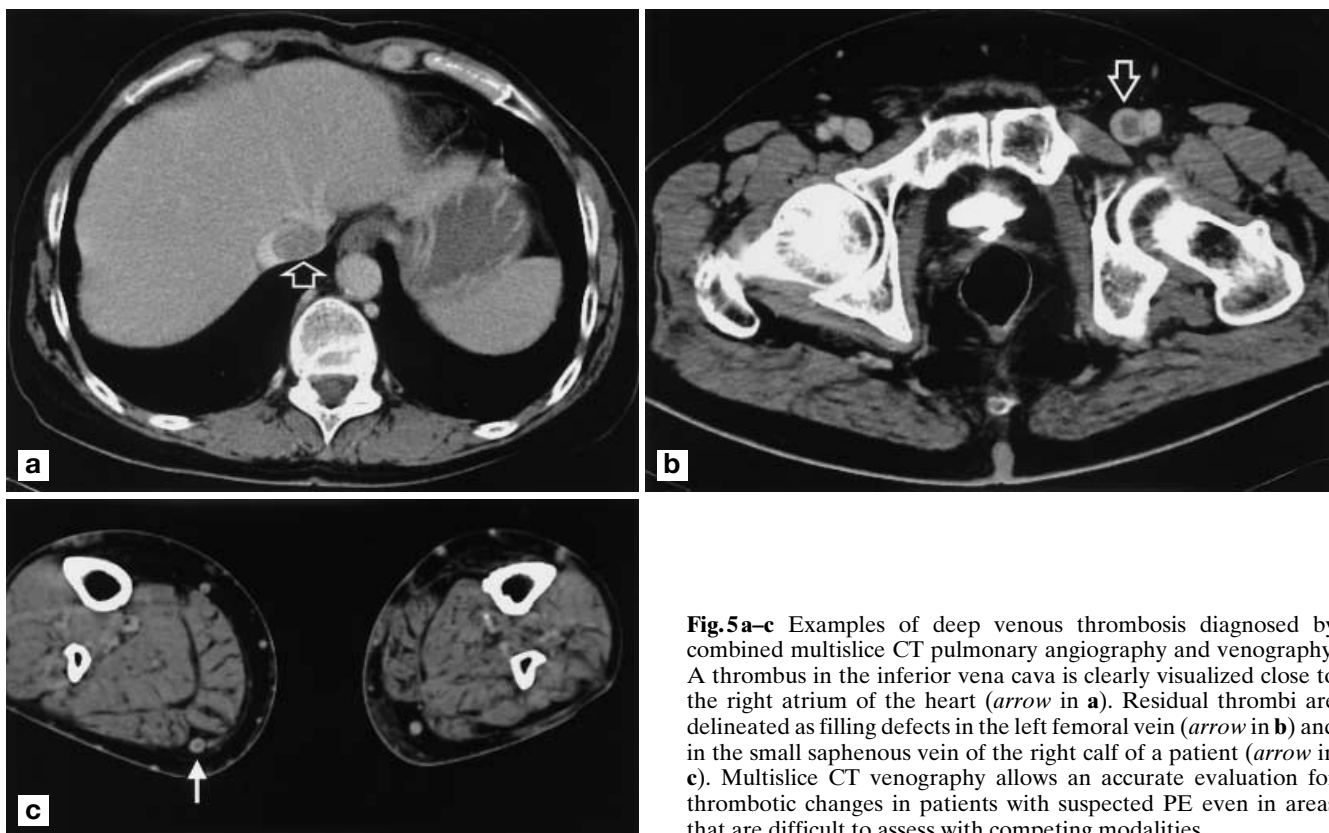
a-c Examples of deep vein thrombosis diagnosed by combined multislice CT pulmonary angiography and venography. A thrombus in the inferior vena cava is clearly visualized close to the right atrium of the heart (*arrow in a*). Residual thrombi are delineated as filling defects in the left femoral vein (*arrow in b*) and in the small saphenous vein of the right calf of a patient (*arrow in c*). Multislice CT venography allows an accurate evaluation for thrombotic changes in patients with suspected PE even in areas that are difficult to assess with competing modalities
